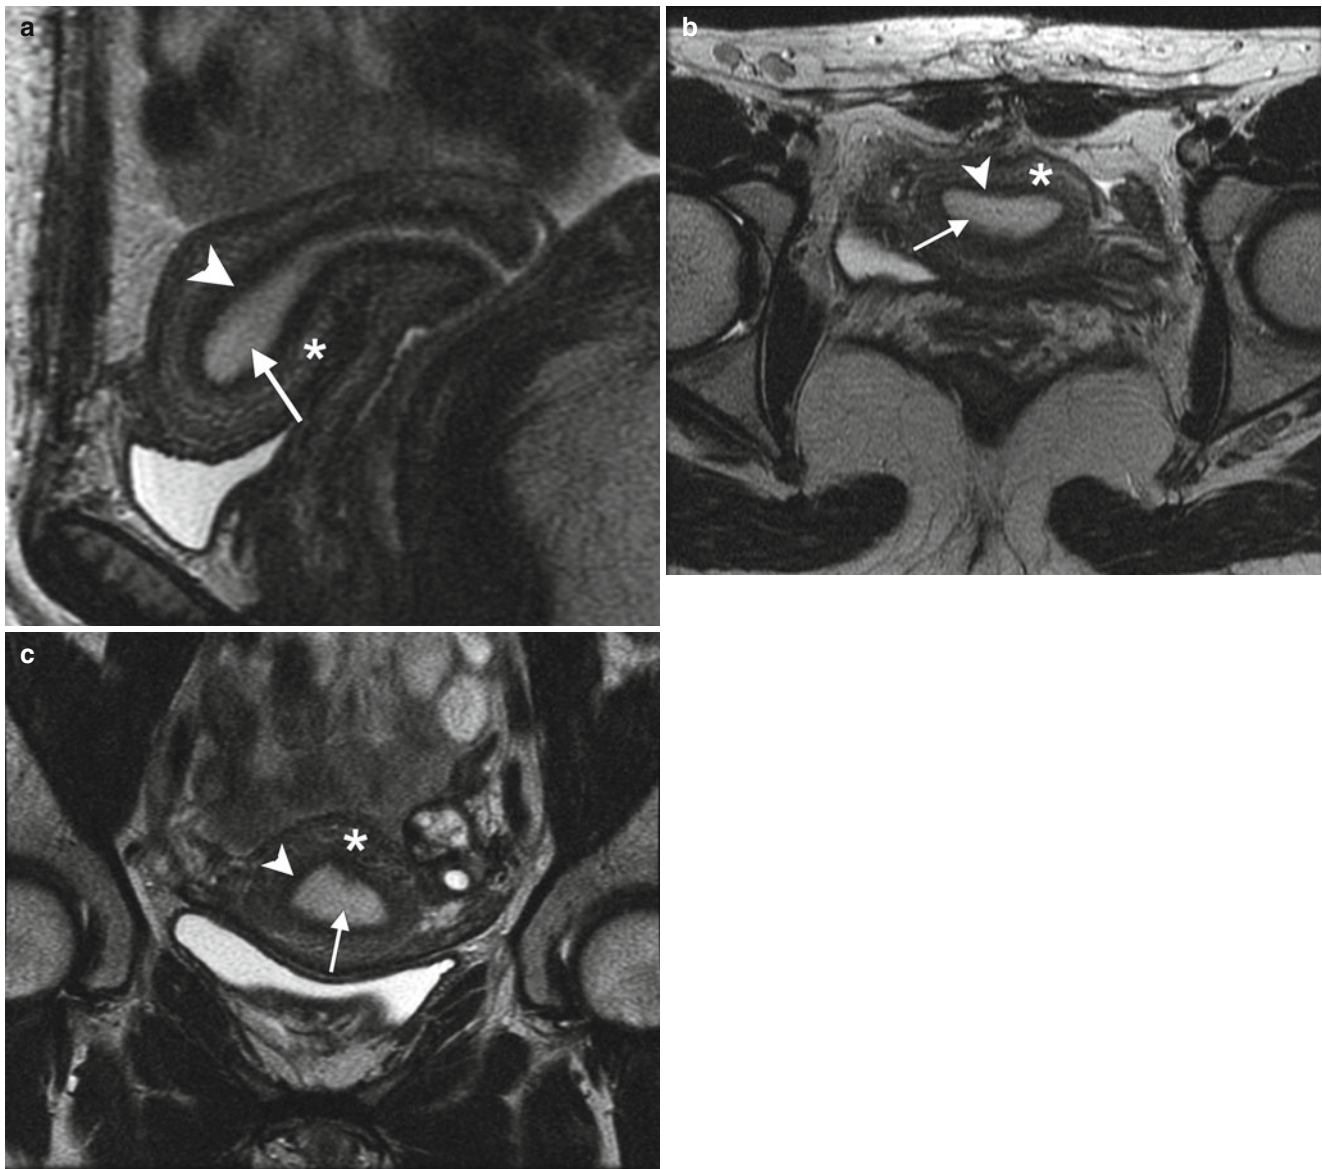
Zonal anatomy of the normal uterus. T2-weighted sagittal (a), axial (b), and coronal (c) images demonstrate the normal uterine zonal anatomy in a premenopausal woman, including the endometrium (arrows), junctional zone (arrowheads), and outer myometrium (asterisks)
